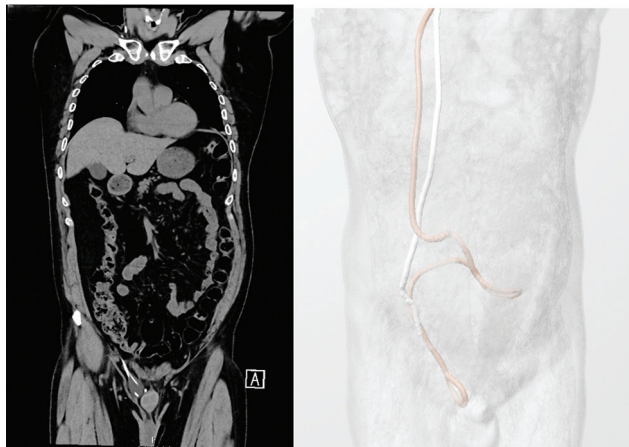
Left: Coronal computed tomography (CT) scan showing both catheter ends in the inguinal sac hernia on the right side (orange circle) with the hernia cavity filled with cerebrospinal fluid (CSF). Right: Three-dimensional (3D) depiction of the distal catheters, with tips located in an inguinal hernia.
